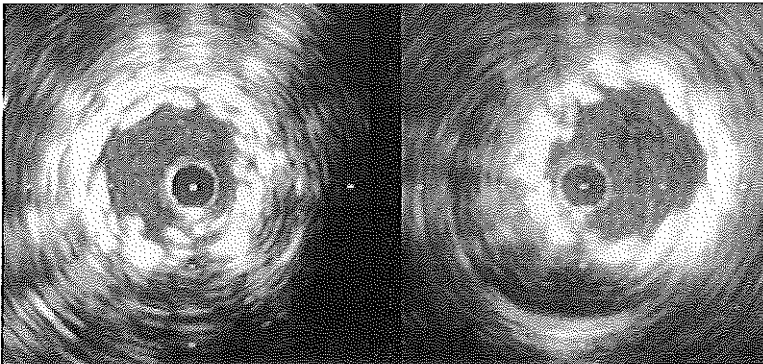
Corresponding intravascular ultrasound cross-sections obtained in the iliac part of an AneuRx stent-graft showing stenosis and folding. After additional balloon angioplasty mean lumen diameter increased from 6.5 to 8.5 mm and the folding diminished. Calibration = 5 mm.
